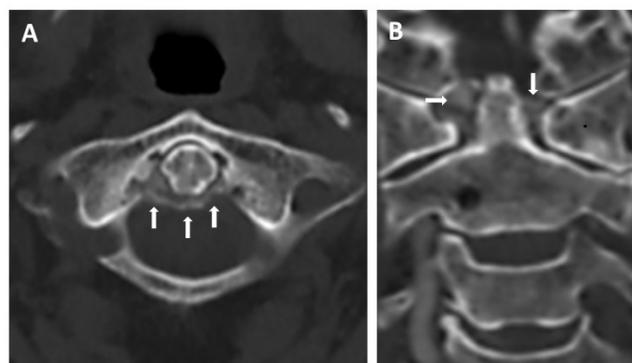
Computed tomography of the neck shows curvilinear calcifications of the transverse ligament of the atlas (Panel A, arrows) and crown-shaped calcium deposits surrounding the odontoid process (Panel B, arrows).
